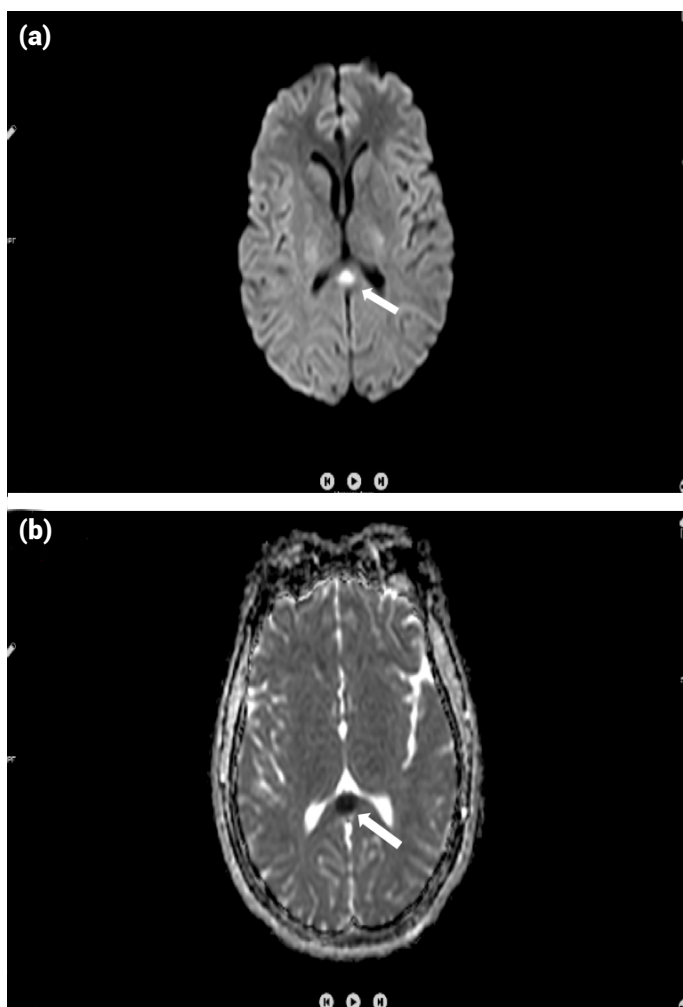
Case 2; (a) Acute diffusion restriction in the corpus callosum on diffusion MRI; (b) The corresponding anatomical parts exhibited hypo intensity on the ADC.
